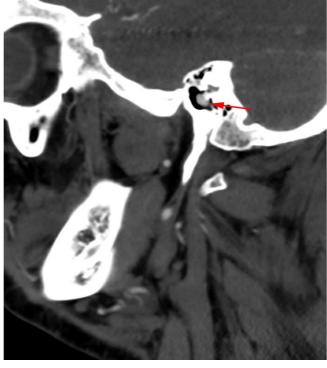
Axial (top) and sagittal (bottom) CT angiographic images of the head demonstrate an aberrant left ICA coursing through the temporal bone, superficial to the cochlear promontory. Patients with this variant anatomy occasionally present with pulsatile tinnitus. A pulsatile retrotympanic mass is commonly seen on otoscopy.
